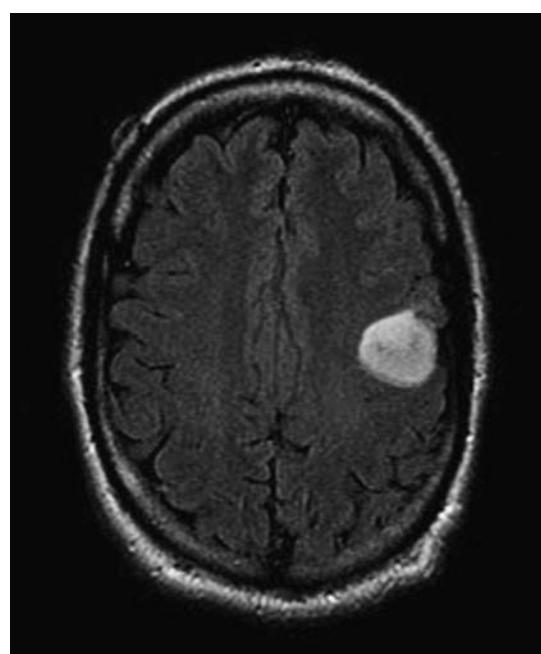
Fluid-attenuated inversion recovery (FLAIR) MRI of a left frontal low-grade astrocytoma. This lesion did not enhance.
